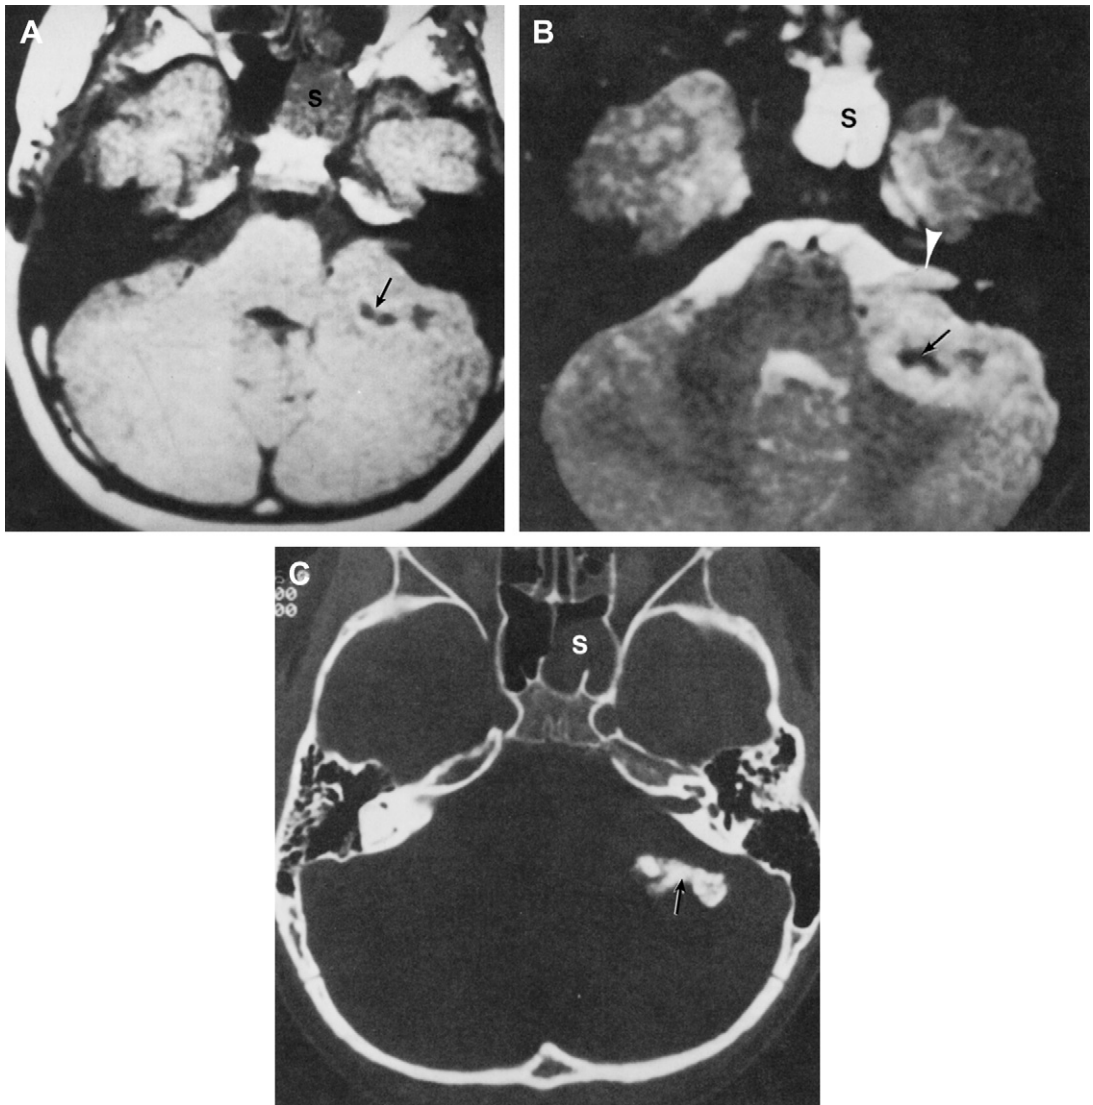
Cerebellar astrocytoma with extension into the internal auditory canal in a 7-year-old boy. (A) Axial T₁-weighted image shows lesion in the CPA cistern. The low signal area (*arrow*) does not represent fluid but calcium. (B) T₂-weighted image again shows the low signal of the calcified region (*arrow*). The lesion protrudes into the internal auditory canal (*arrowhead*). (C) Computed tomography demonstrates calcification (*arrow*). Note the secretions (S) in the left sphenoid sinus.
